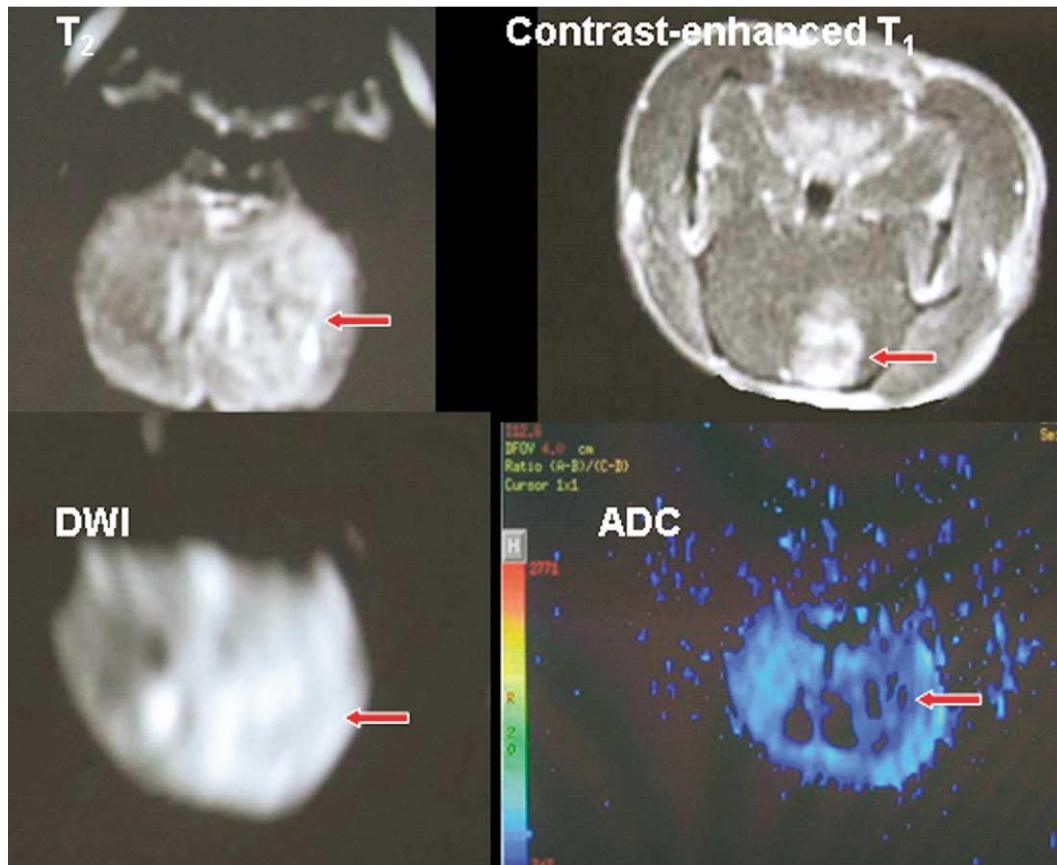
Magnetic resonance imaging (MRI) of C6 gliomas 3 weeks after C6 cell implantation. (a) T₂-weighted images. (b) Contrast-enhanced T₁-weighted images. (c) diffusion-weighted MRI (DWI). (d) Apparent diffusion coefficient (ADC) map. The signal intensity in the solid portion of the tumor was hyperintense on DWI ($b = 1,000$) and hypointense on ADC map with respect to the white matter.
